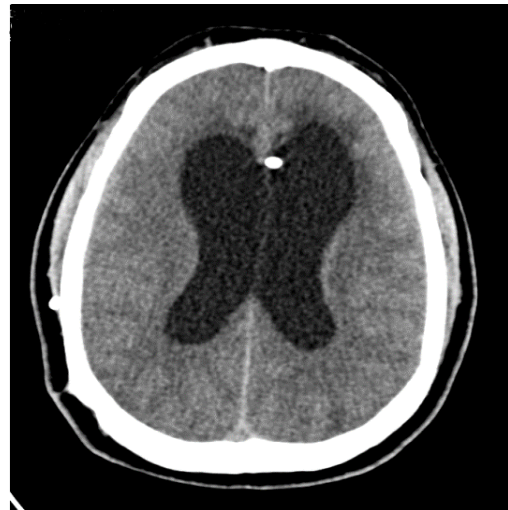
CT showing hydrocephalus and VP Shunt.
